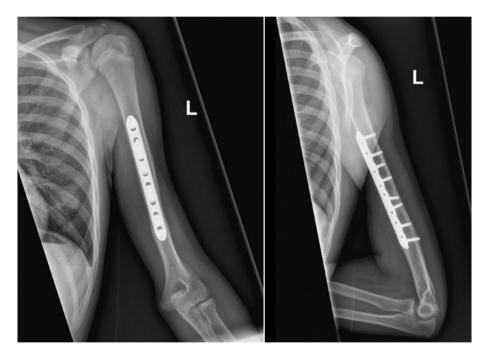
(a-b): Plain film radiographs of left humerus one year after surgery, showing healed fracture without signs of hardware failure.
